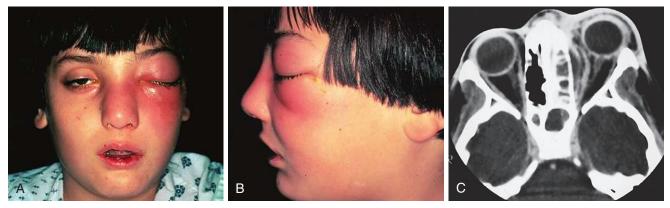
Orbital subperiosteal abscess. A and B, This child had a fever, severe toxicity, and marked lethargy. He experienced intense orbital and retro-orbital pain and showed a limited range of ocular motion with associated exacerbation of pain. C, This CT scan shows preseptal swelling, proptosis, and lateral displacement of the globe and orbital contents by a subperiosteal abscess.
